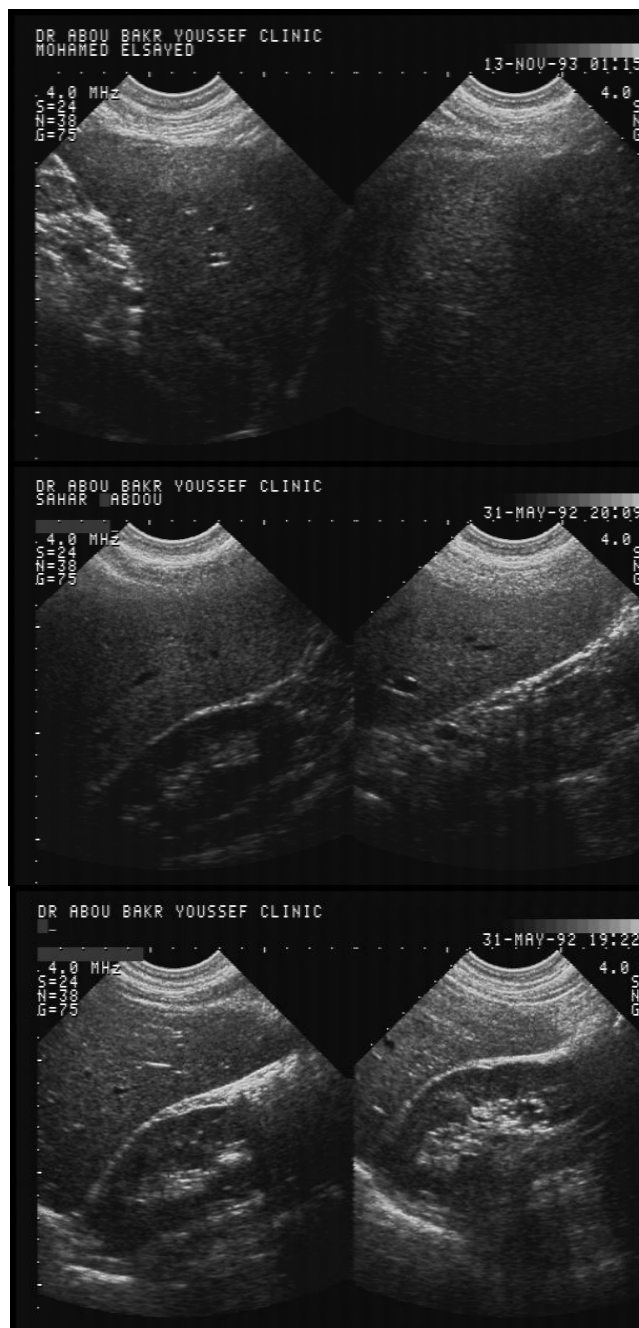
Normal, Fatty, and Cirrhotic B-mode ultrasound images acquired at 4 MHz .
